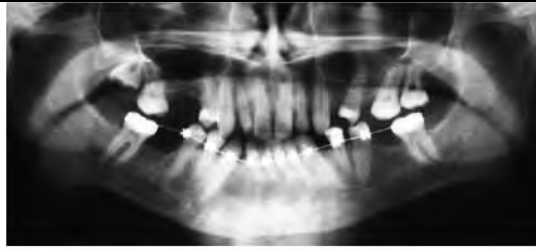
Orthopantomogram. Sixty-two months after decompression.
